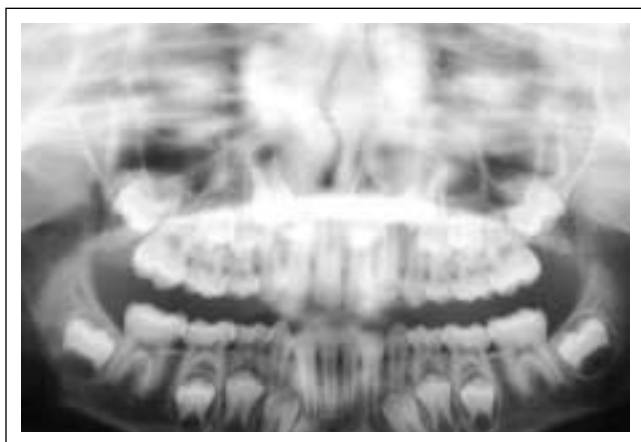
The panoramic radiograph made nine months after the beginning of the functional therapy: a remodeling of the left condyle is evident (arrow).
